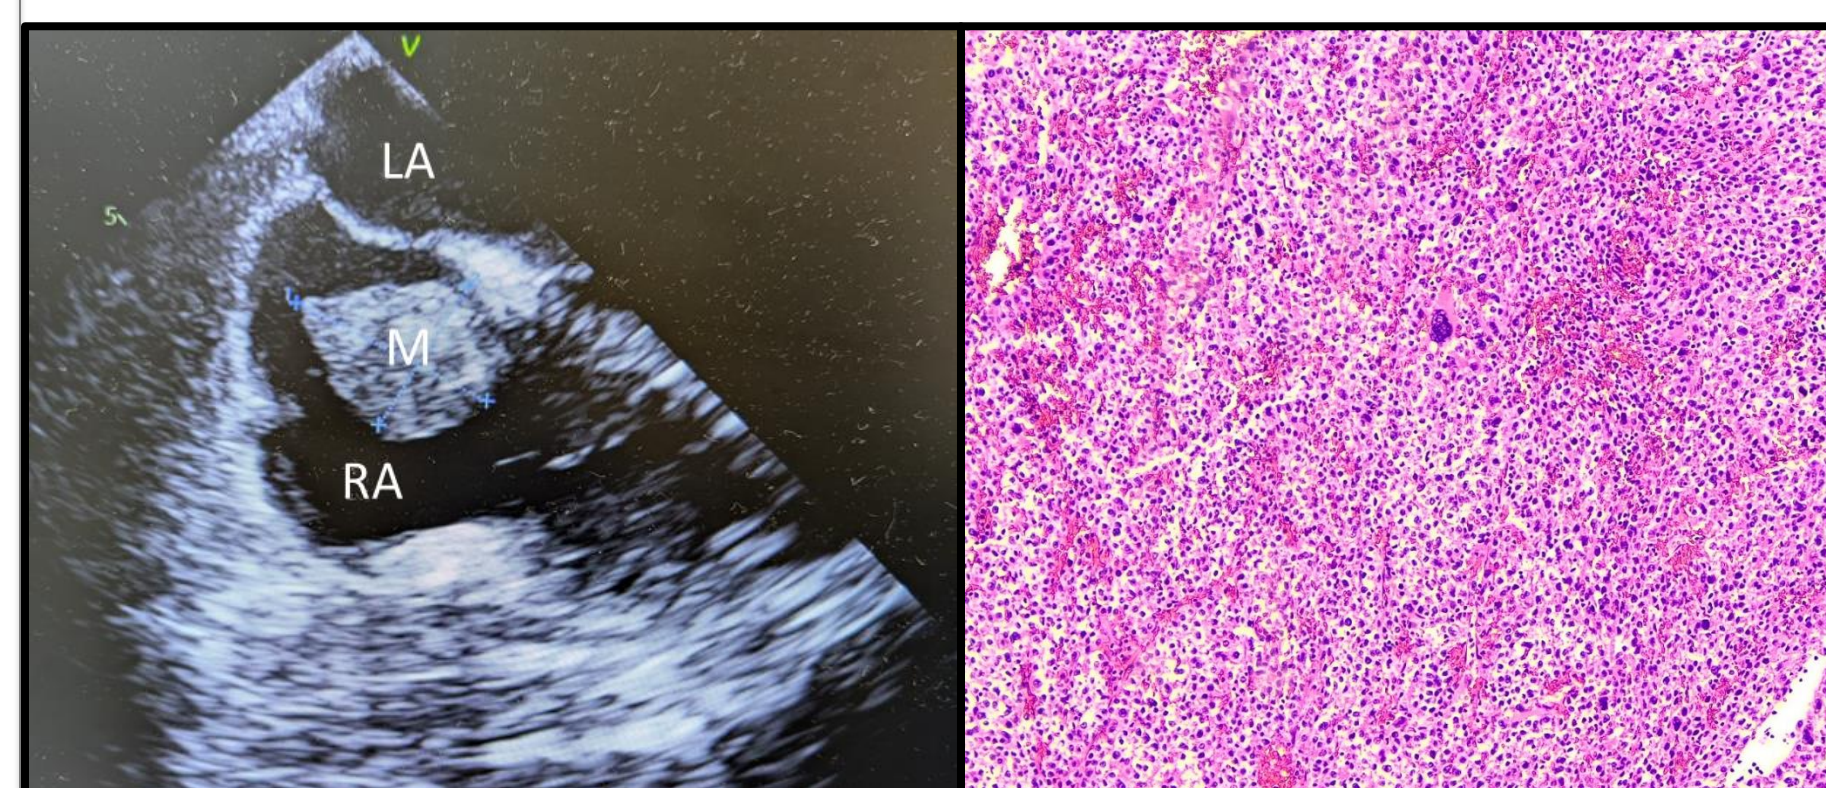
Echocardiogram (LA – left atrium; M – mass; RA – right atrium)
